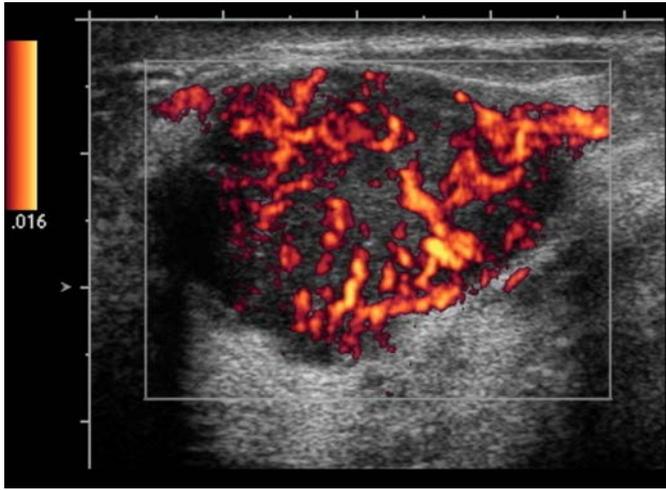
(a) A power mode colour Doppler image showing the vascularity in a breast mass. Compared to Figure 7.31 it is much easier to assess the distribution of the vessels in this image. Note the colour bar now shows how the colour varies with signal strength.
